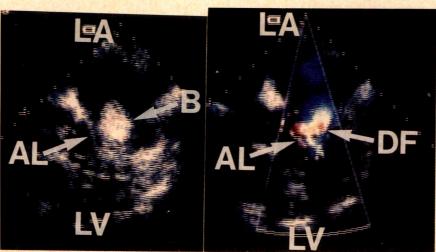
Transesophageal 2-dimensional echocardiogram and color flow Doppler in a patient undergoing percutaneous double balloon valvotomy. *Left*, both balloons inflated across the mitral valve. *Right*, the color flow Doppler shows a mosaic color pattern indicating a high velocity flow between both balloons during inflation. AL = anterior leaflet; B = balloons; DF = diastolic flow; LA = left atrium; LV = left ventricle.
